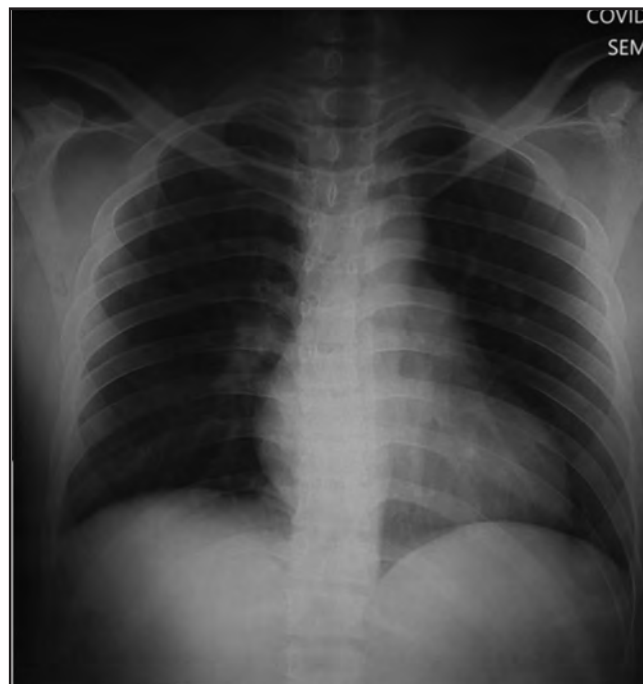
Chest X-ray showed clear lung field.
